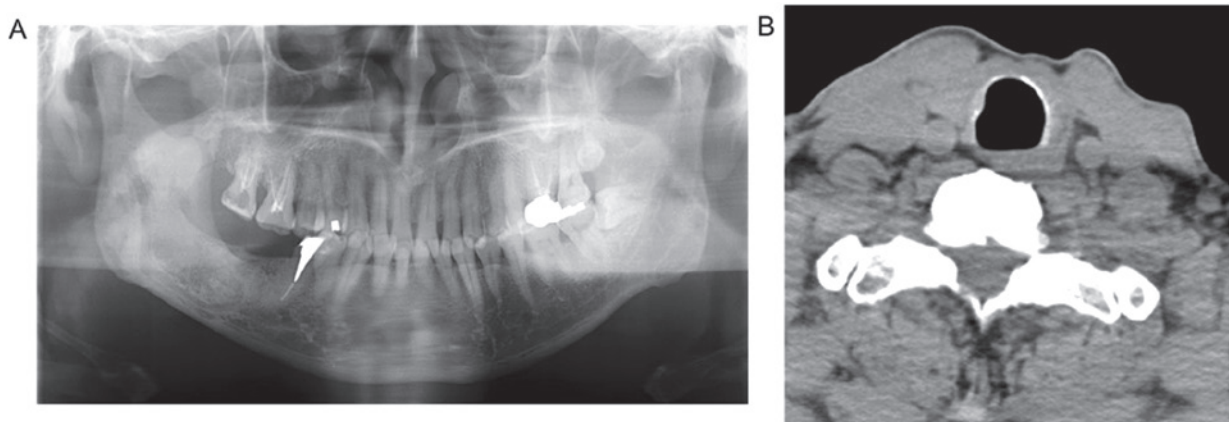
Follow up of patient. (A) Panoramic image shows no recurrence of the mandibular lesion and (B) CT image 10 years after total thyroidectomy shows no recurrence lesion on thyroid area.
